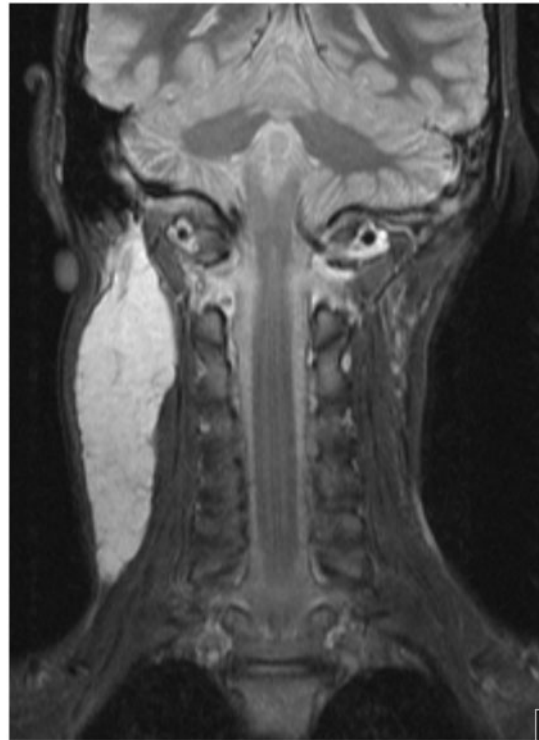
Coronal T2-weighted magnetic resonance image of the head and neck showing a large hyperintense mass extending from the level of the submandibular gland inferiorly to the root of the neck.
